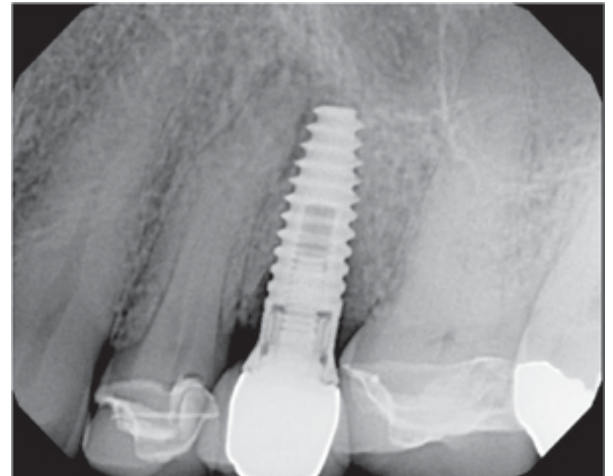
Periapical of the final implant retained crown.
